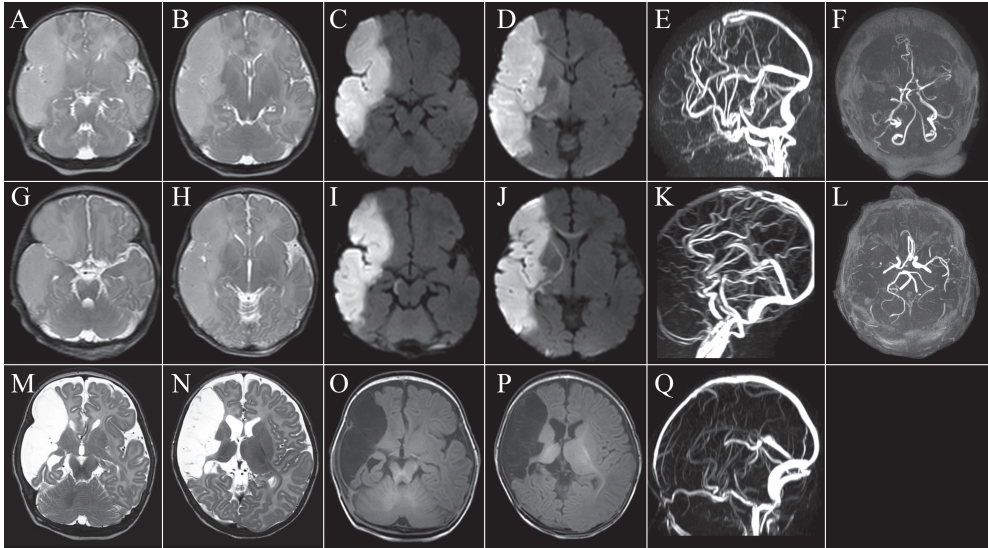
MRI of Case 2. MRI of a newborn (case 2) with a rare combination of PAIS and CSVT who had three MRIs: the first at 24 hours (upper row) and the second at 72 hours after onset of symptoms (middle row) and the third at three months of age (bottom row). Compared to the first scan there was an increase in signal intensity in the right cerebral peduncle (A versus G) and PLIC (B versus H) on axial T2 weighted imaging at the second scan. On early axial DW imaging very little signal intensity changes were observed in the cerebral peduncle (C), while a hyperintense signal was seen at 72 hours after onset of seizures (I). Signal changes in the PLIC on DW imaging were clear after 72 hours (J), but not on the first MRI (D). MRV (sagittal view) showed initially no flow in the anterior part of the superior sagittal sinus (E), and recurrence of flow in the sinus on the second MRV after treatment with low molecular weight heparin (K). On MR angiography (axial view) there was persistent hypoperfusion of the right MCA until 72 hours after onset of seizures (F and L). At the age of three months a large cyst had developed in the right hemisphere (M-N). Additionally, there was Wallerian degeneration seen in the descending right CST involving both the cerebral peduncle (O) and the PLIC (P). On MRV flow in the superior sagittal sinus had restored completely (Q).
